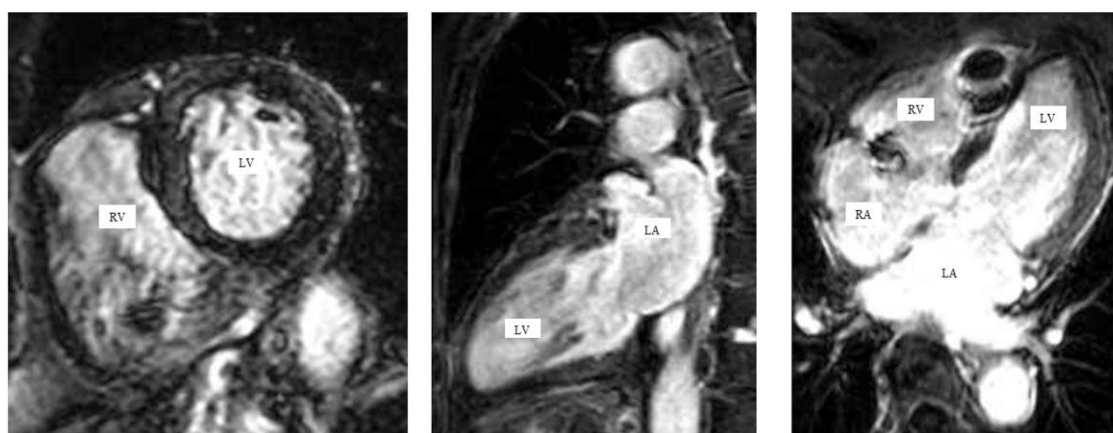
Cardiac magnetic resonance imaging showed normal left ventricular ejection fraction and mass, while gadolinium enhancement delayed imaging showed no delayed contrast.
